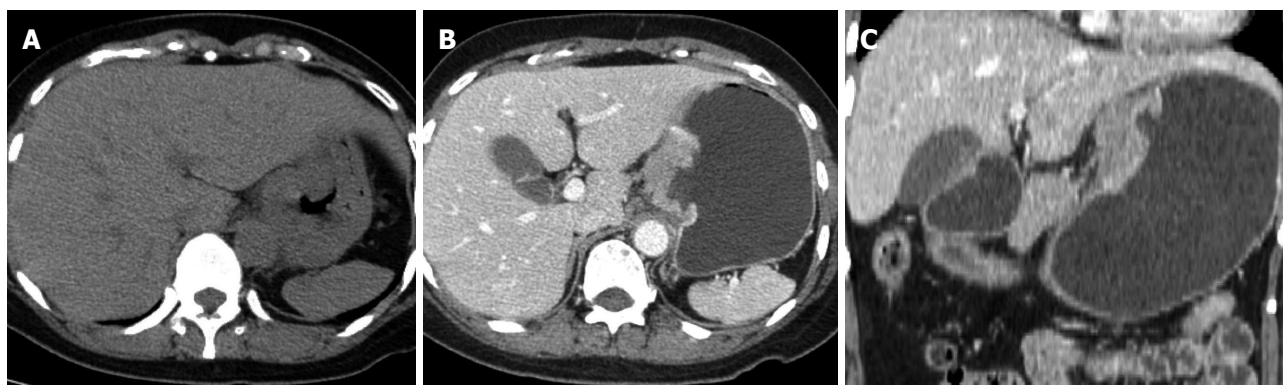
Abdominal computed tomography scan showed focal irregular thickened gastric wall and a ulcerated soft tissue mass formation with heterogeneously obvious enhancement in the lesser gastric curvature and fundus area. A: Plain scan; B: Contrast-enhanced scan; C: Coronal multiplanar reconstruction of enhancement scan.
